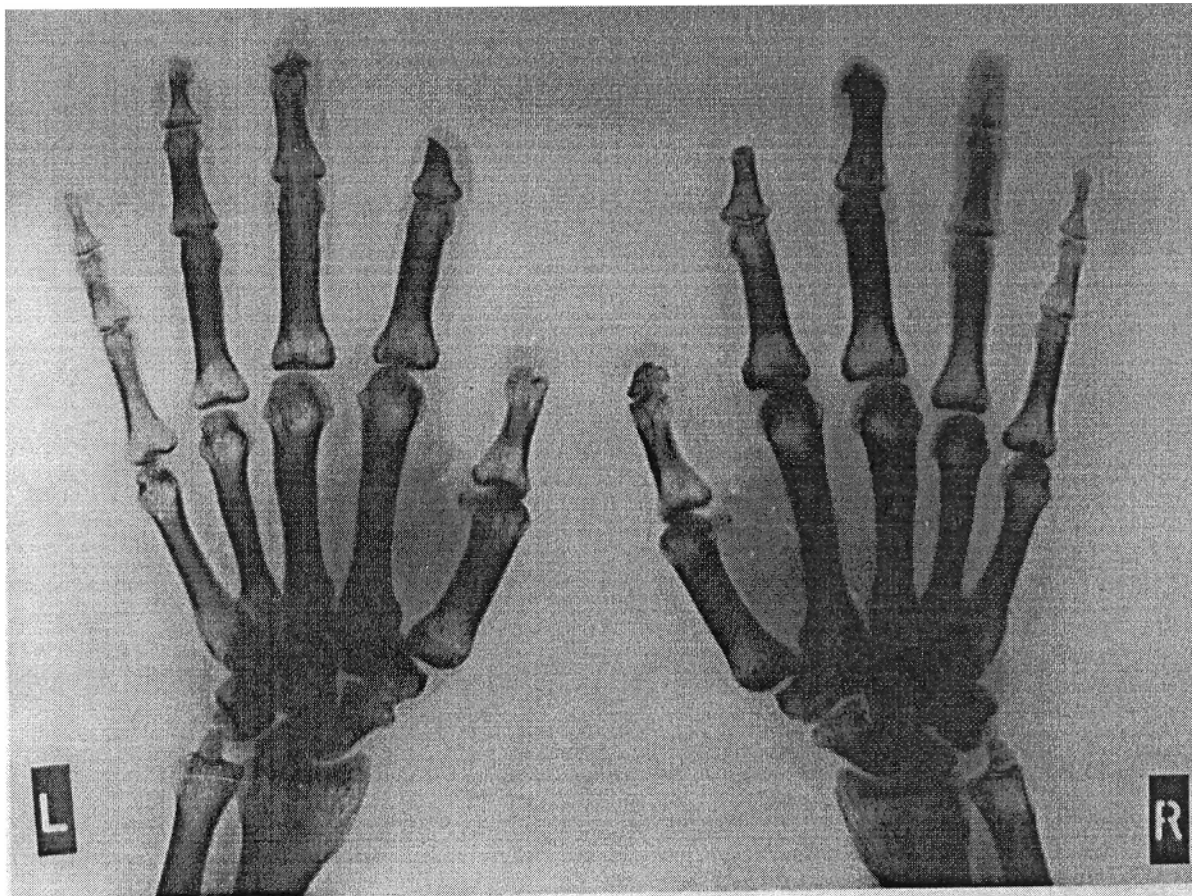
X-ray of the affected hands of the subject 5y after exposure to an estimated dose of 24 Gy to the fingertips and 2-3 Gy to the body. The fingertips have been subject to repeated surgeries to remove the progressively abscessed tissues. The bones at the fingertips appear to have grown brittle due to reduction of bone density.
